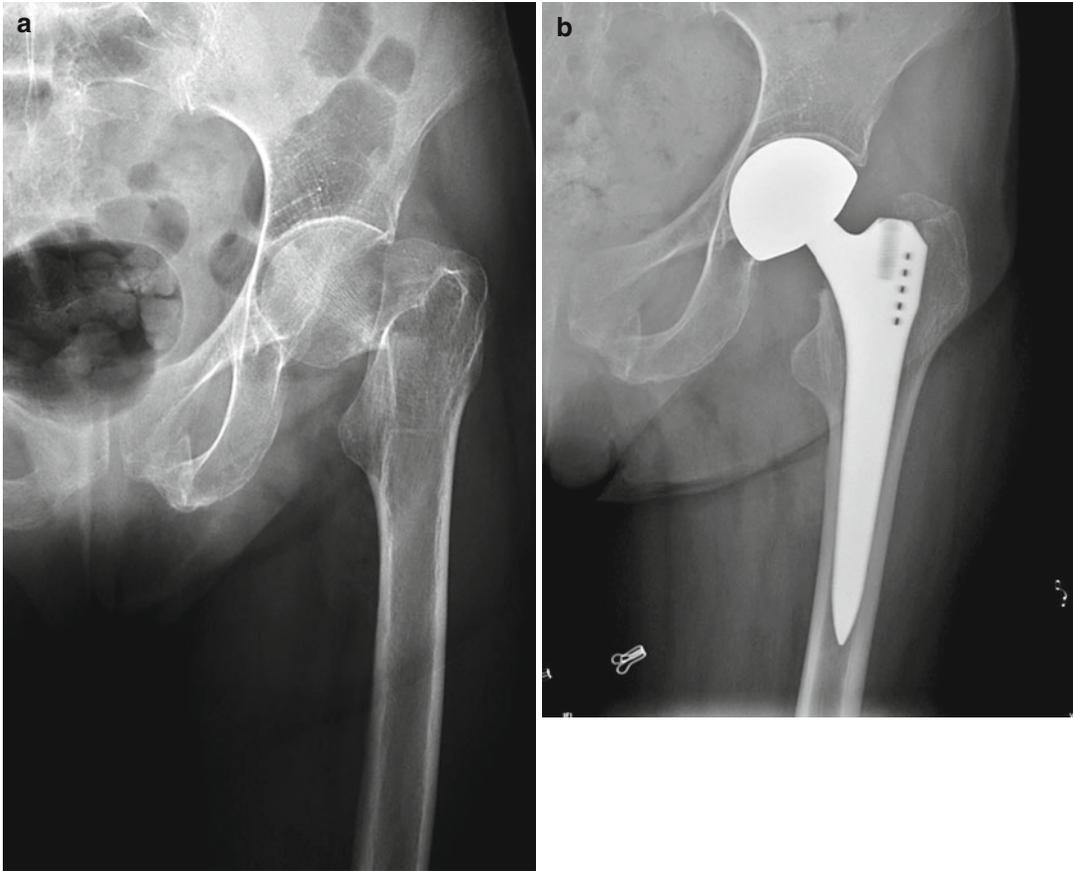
(a) Radiograph of a femoral neck fracture in an 88-year-old female patient with an osteoporotic femur. (b) Postoperative radiograph at 2 years follow-up
